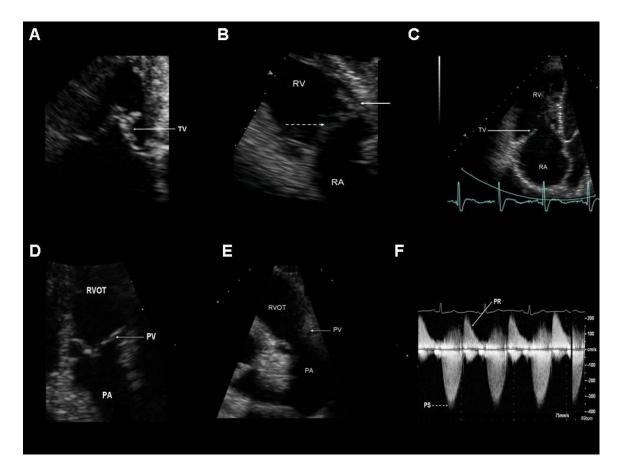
Two dimensional transthoracic echocardiogram. Right atrium (RA),right ventricle (RV), right ventricular outflow tract (RVOT), pulmonary artery (PA).
